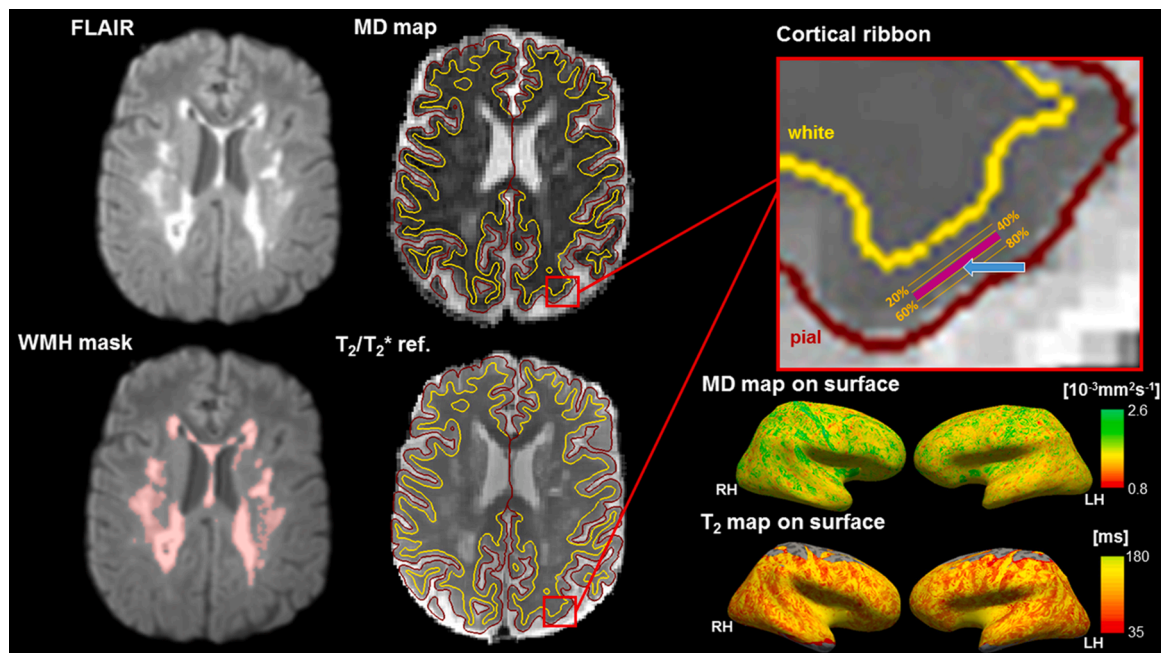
Left: Representative FLAIR image used for segmentation of WMH (top) and FLAIR image with segmented binary WMH mask, shown as overlay (bottom, red). Centre: Data used for registration to the individual anatomical image: MD map (top) and T₂/T₂* reference images (bottom). Data are shown after boundary-based registration to the individual anatomical image with the inner (white matter surface, yellow) and the outer (pial surface, red) cortical boundary shown as surface overlays.
